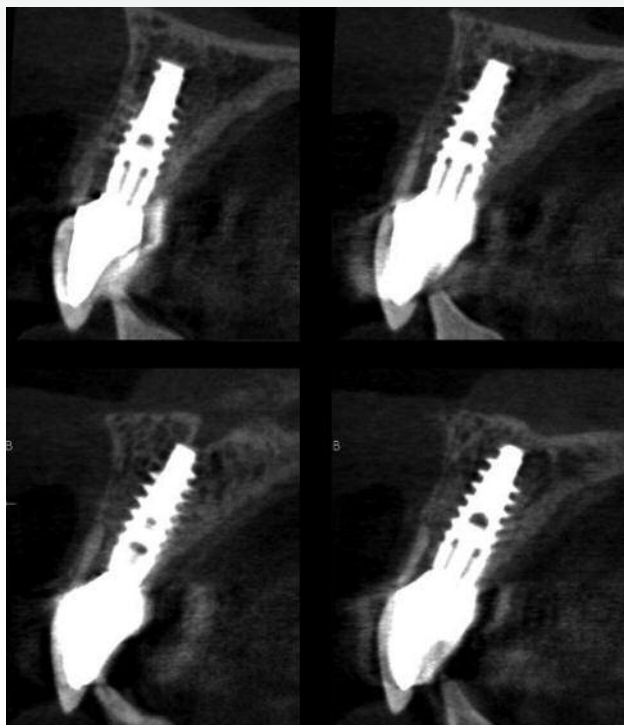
CBCT scans of the 2-year follow-up, site 11 above, site 21 below
